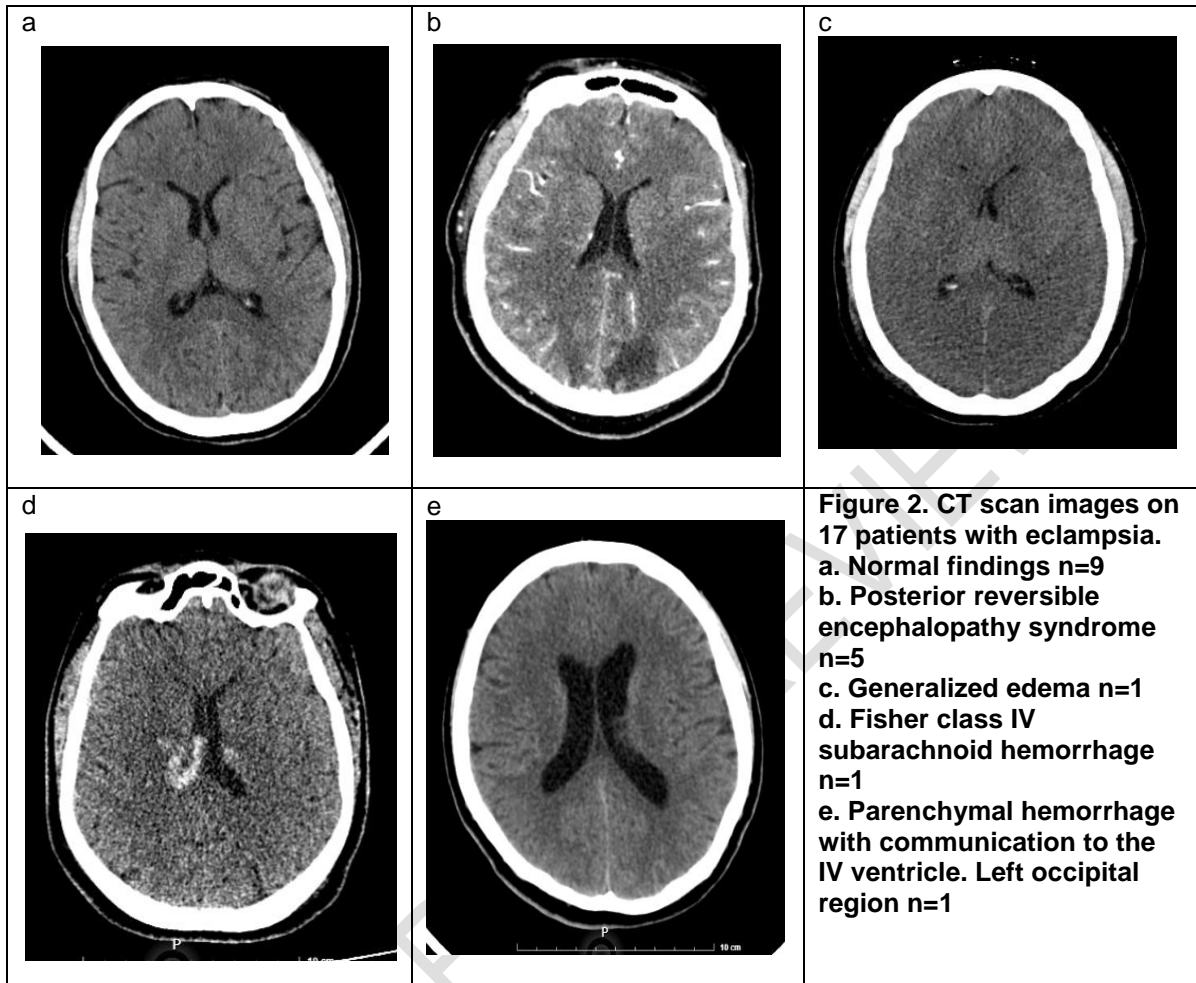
Distribution of Computerized Tomography scan and Magnetic Resonance Imaging findings performed on 17 patients with eclampsia.
